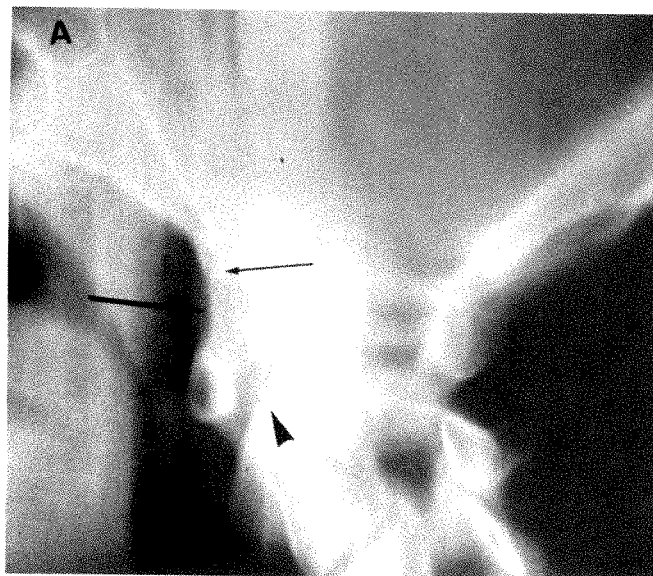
Lateral (A) and anteroposterior (B) radiographs of craniovertebral region in 31-year-old male with multiple upper cervical anomalies. Note absent dens, moundlike summit of C2 (*arrowhead*), and third occipital condyle (*thin arrow*) articulating with an os odontoideum (*thick arrow*). Patient also had coarcted foramen magnum (see fig. 13).
